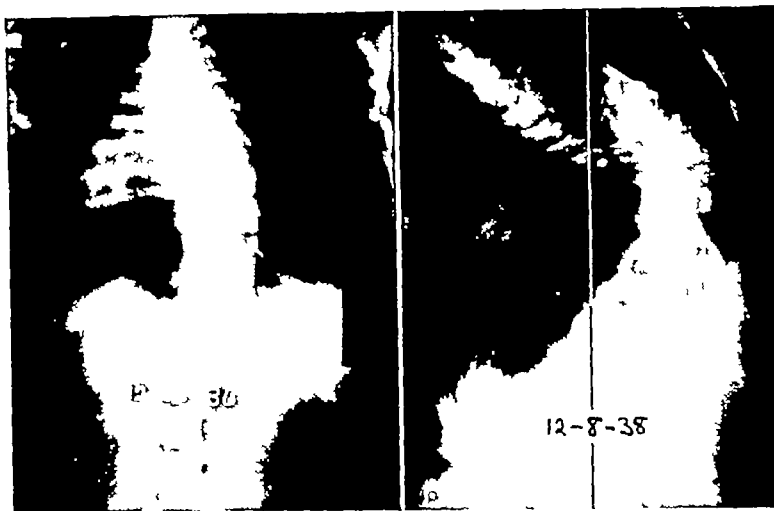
left At the time of this roentgenogram the patient was 11 years of age The patient had been treated with exercises, braces, and jackets since she was 7 years of age at which time the curve was first noticed Treatment up to 11 years had been considered satisfactory as the curve had not increased to any appreciable extent The years from 11 to 14 will mark the rapid growth period for this girl Primary curve from fourth dorsal to second lumbar, apex, tenth dorsal, neutral vertebra is second lumbar
